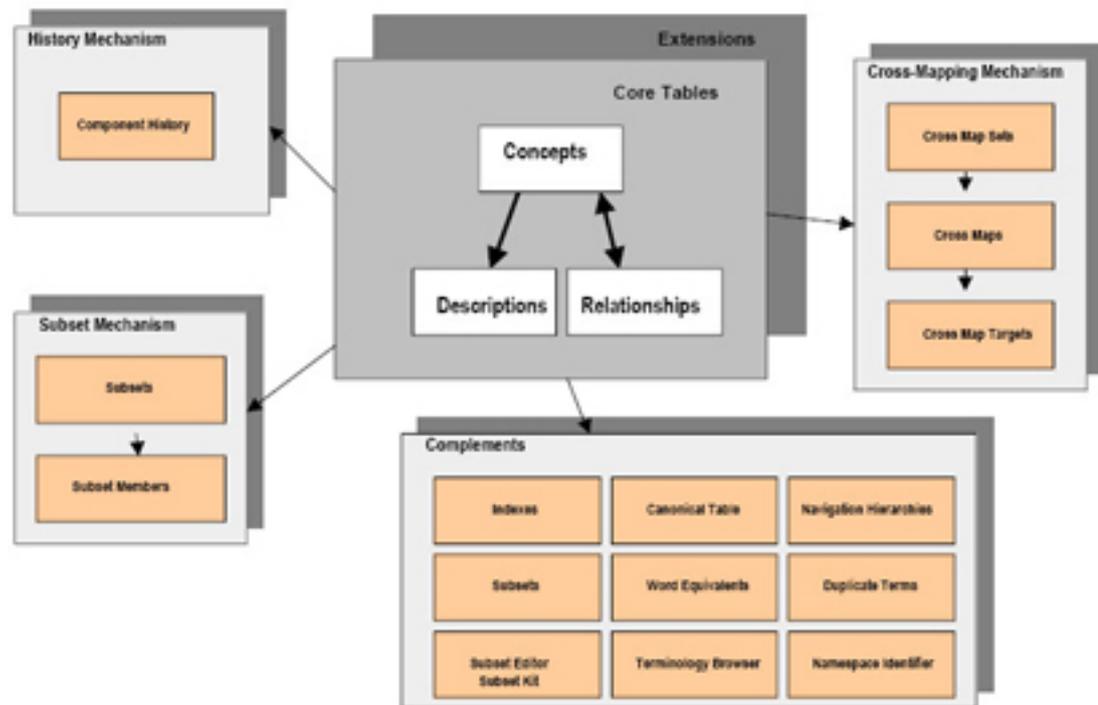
SNOMED CT File Structure: Consists of the Core Tables along with the miscellaneous data files.
